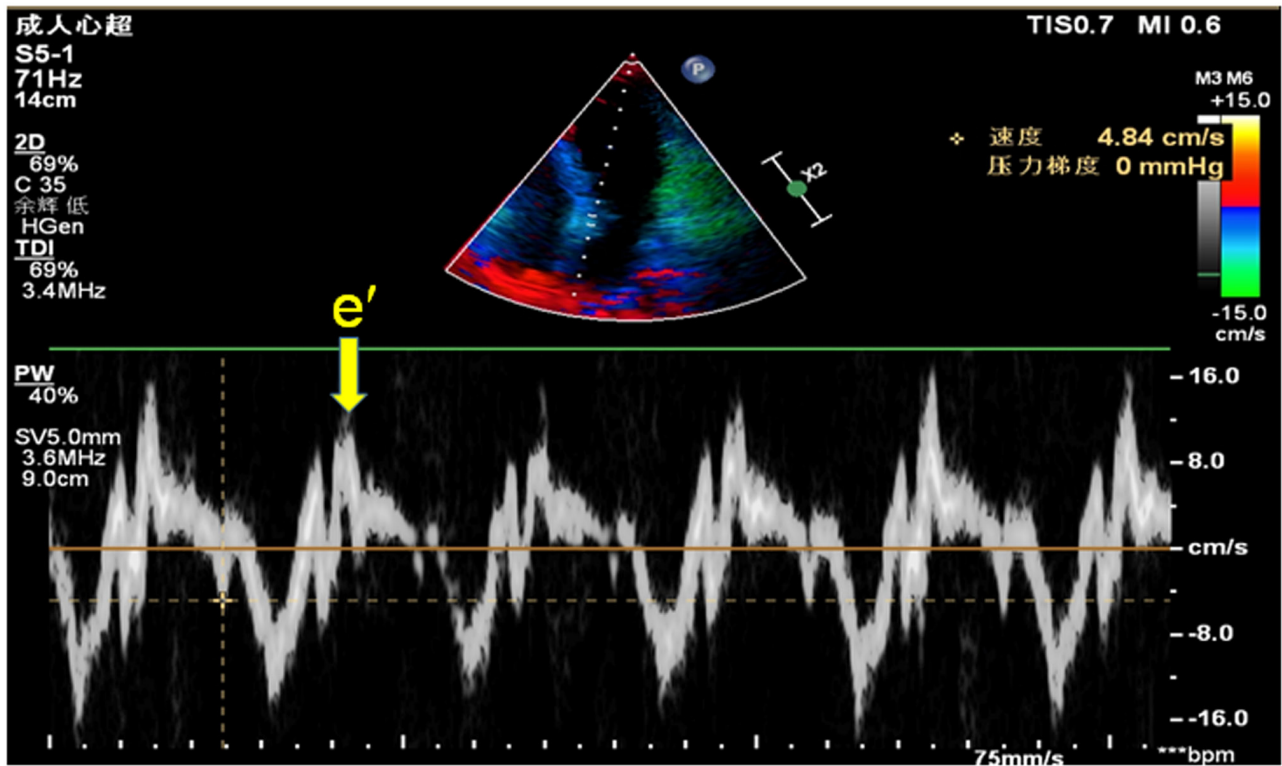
Measurement of the mitral e' peak. Images of the lateral mitral annulus were captured and measured by TDI to obtain the e' peak (arrow). e', early; TDI, tissue Doppler image.
